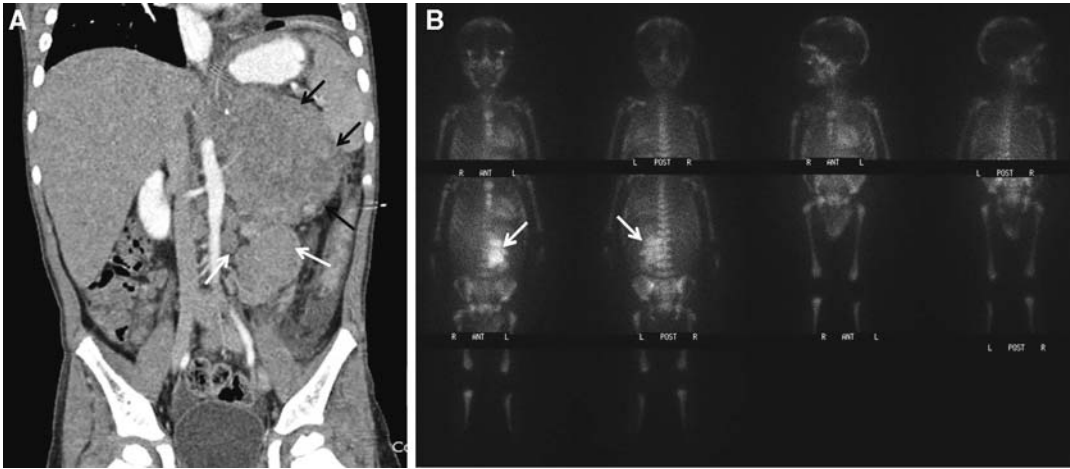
presents a case of metastatic neuroblastoma using bone scintigraphy.
